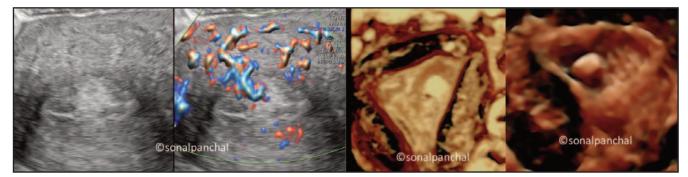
Polyp seen on 2D(a), power doppler, single feeding vessel(b), 3D(c), sonohysterography showing polyp(d).
